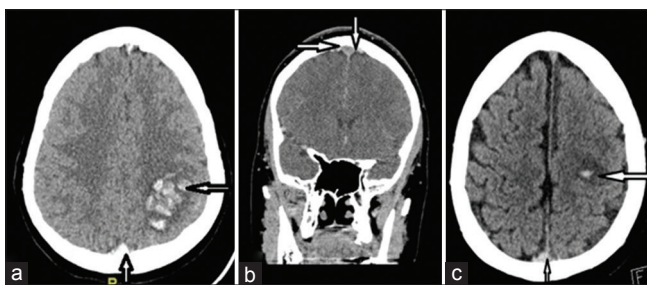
Radiological findings in computed tomography and computed tomography venography of patients with CVST: (a) Plain noncontrast computed tomography scan axial view showing dense triangle sign and left parietal heterogenous hemorrhage in a patient with superior sagittal sinus thrombosis. (b) Coronal image of computed tomography venography of the same patient (a) showing filling defect in superior sagittal sinus. (c) Plain noncontrast computed tomography scan axial view of another patient showing dense triangle sign and left parietal small hemorrhage surrounded by hypodensity in a patient with superior sagittal sinus (these two patients were admitted under our care and relevant permissions were obtained for the use of these images)
